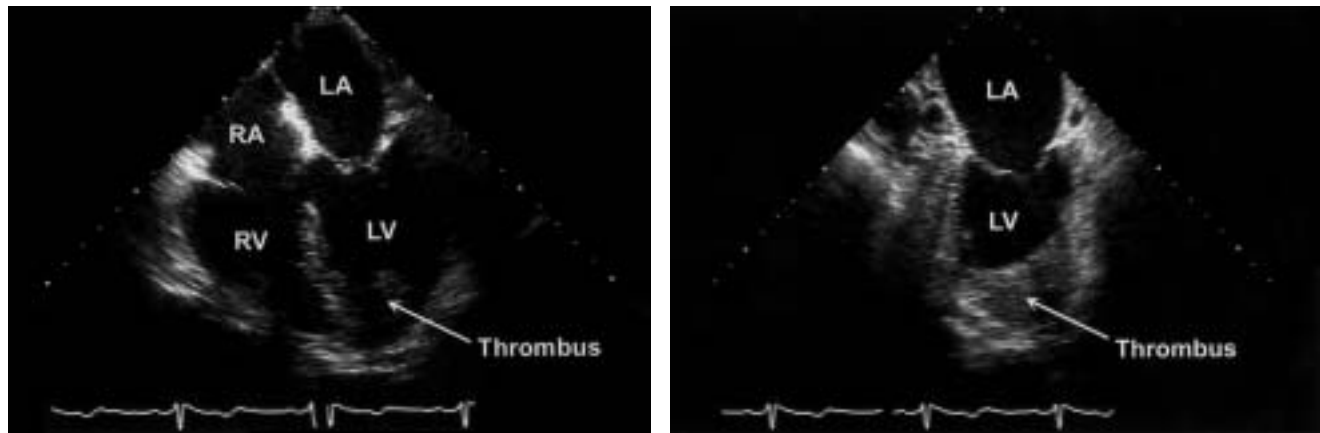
Transesophageal echocardiograms showing a 2.9-cm thrombus occupying the apex of the left ventricle (LV). Left, Four-chamber view. Right, Two-chamber view. LA = left atrium; RA = right atrium; RV = right ventricle.
